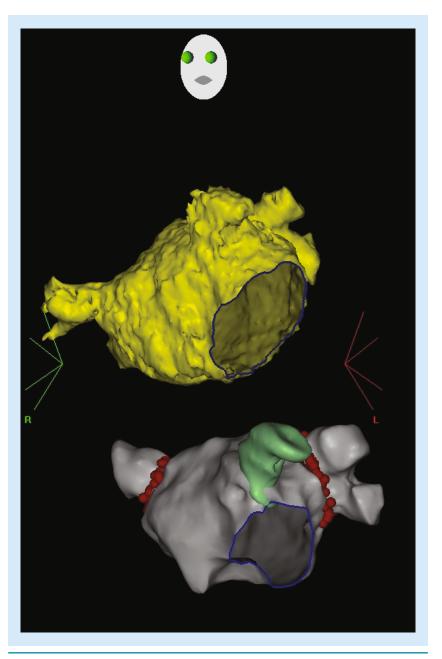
3D electro-anatomical map of the left atrium (gray) and the left atrial appendage (green) in a left anterior oblique projection with circumferential ablation (red points) around ipsilateral pulmonary veins. (A) Using a 3D reconstruction of the MRI of the left atrium (yellow) and (B) an electro-anatomical mapping system (CARTO Biosense Webster Inc.,CA, USA). Please see color figure online at www.futuremedicine.com/doi/full/10.2217/CPR.13.23
